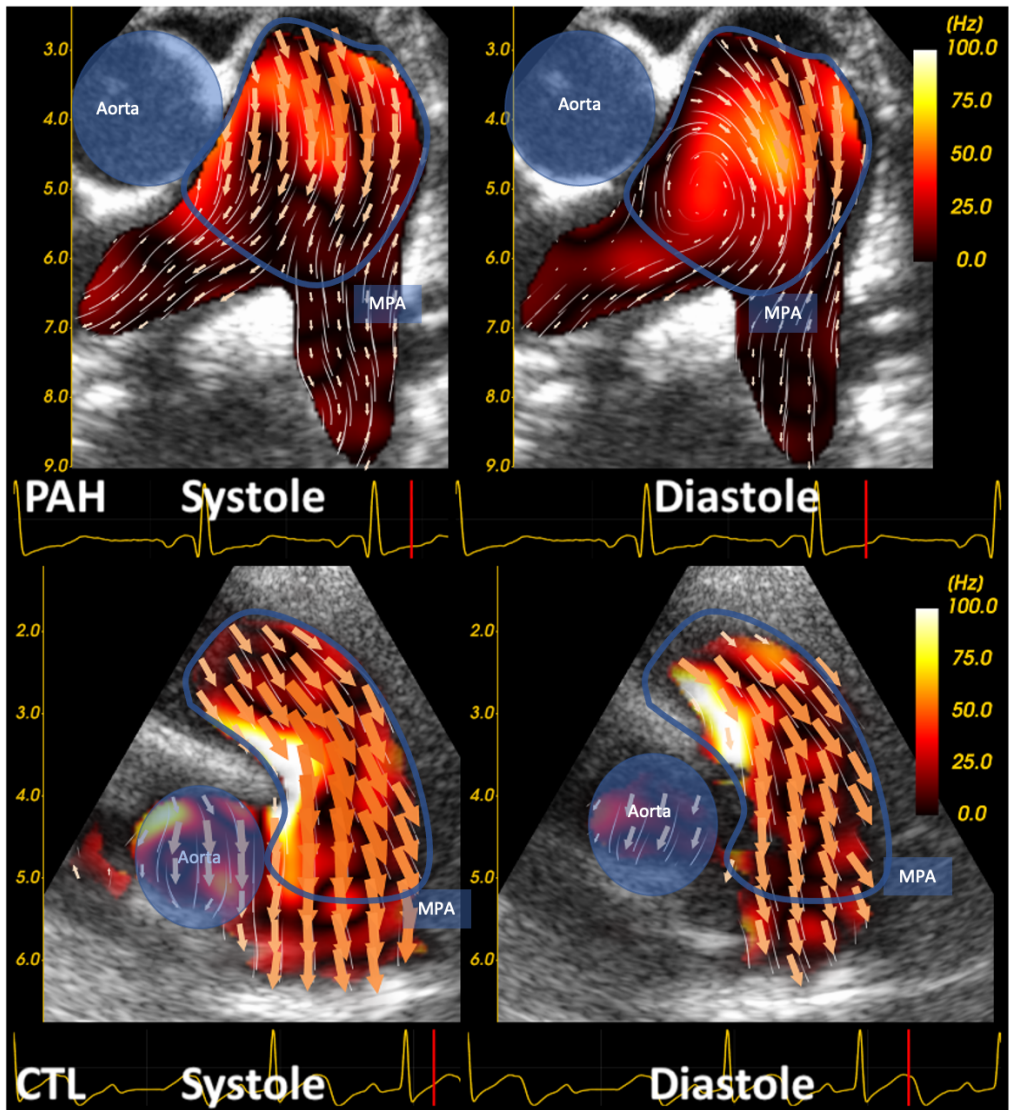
Typical main pulmonary artery flow patterns as shown by high frame rate ultrasound imaging and blood speckle tracking. The vorticity map is seen in the background.
